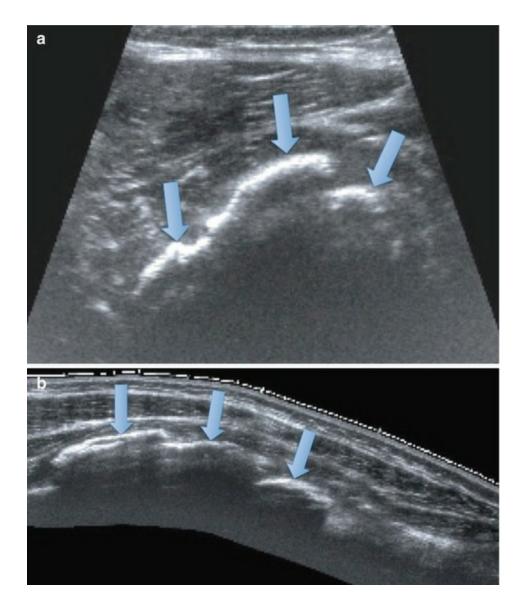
(a, b) 15-year-old-male soccer player 4 weeks after direct contusion on the thigh Axial and sagittal ultrasound images showed extensive hyperechoic rim (*arrows*) with posterior shadowing related to ossification in vastus intermedius muscle in keeping with myositis ossificans
